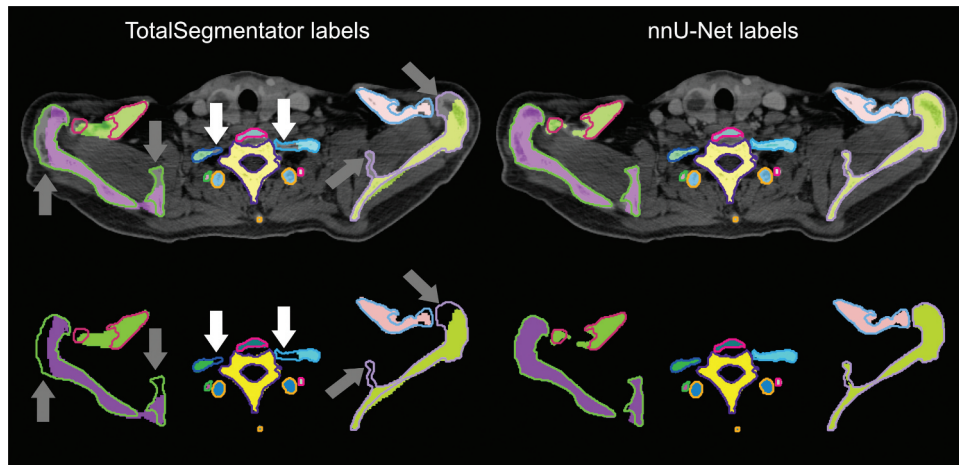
Comparison of manual labels (contours) and predicted labels (area) by the TotalSegmentator (left) and the custom trained nnU-net (right) on the CT scan (upper) and solely (lower). Pronounced deviations of the TotalSegmentator labels are between the ribs and the vertebra (white arrows) as well as in the segmentation of the scapulae (grey arrows). Different colors indicate different bones.
